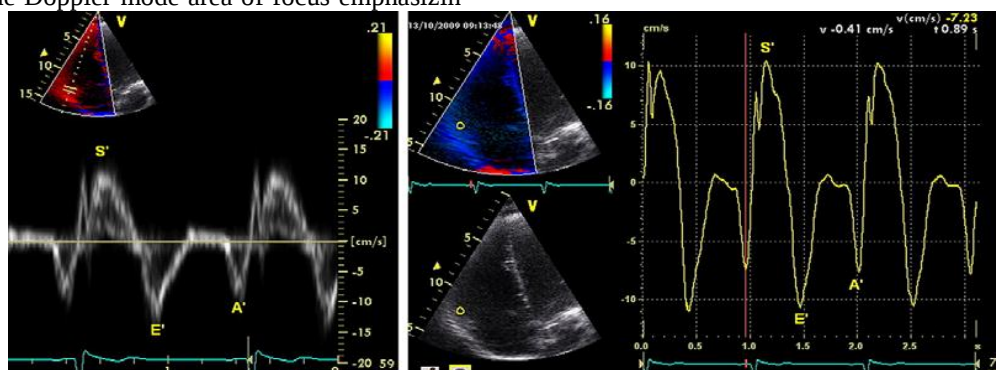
Left: Pulsed Doppler and right : Color-coded offlin e examin ation of the tricuspid annulus in a patient with normal right ventricular systo lic function.
